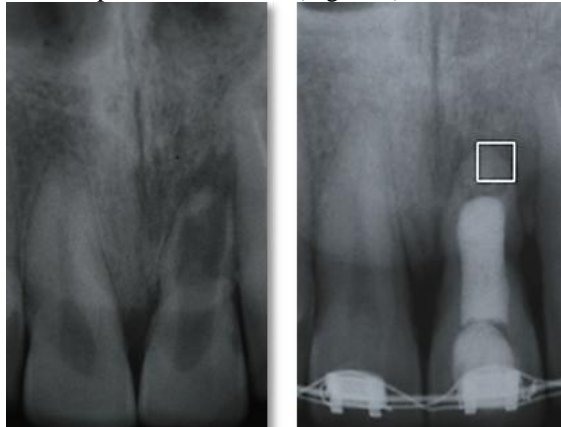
Application of bioceramic of calcium phosphate into zone and biomimetic approach to apical control zone (pre- and postoperative radiograph).
